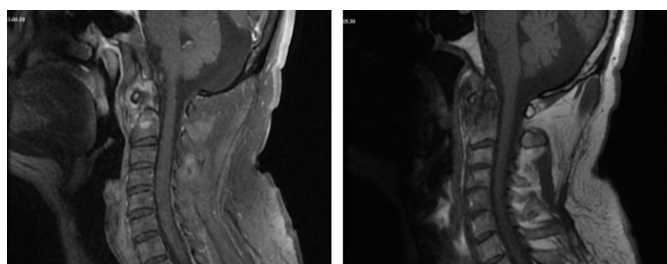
Magnetic resonance imaging showing the distinct signal alterations at the C2 vertebra level and atlantoaxial distention. These alterations are evident in both the sagittal short tau inversion recovery and sagittal T1 fast recovery fast spin echo images
